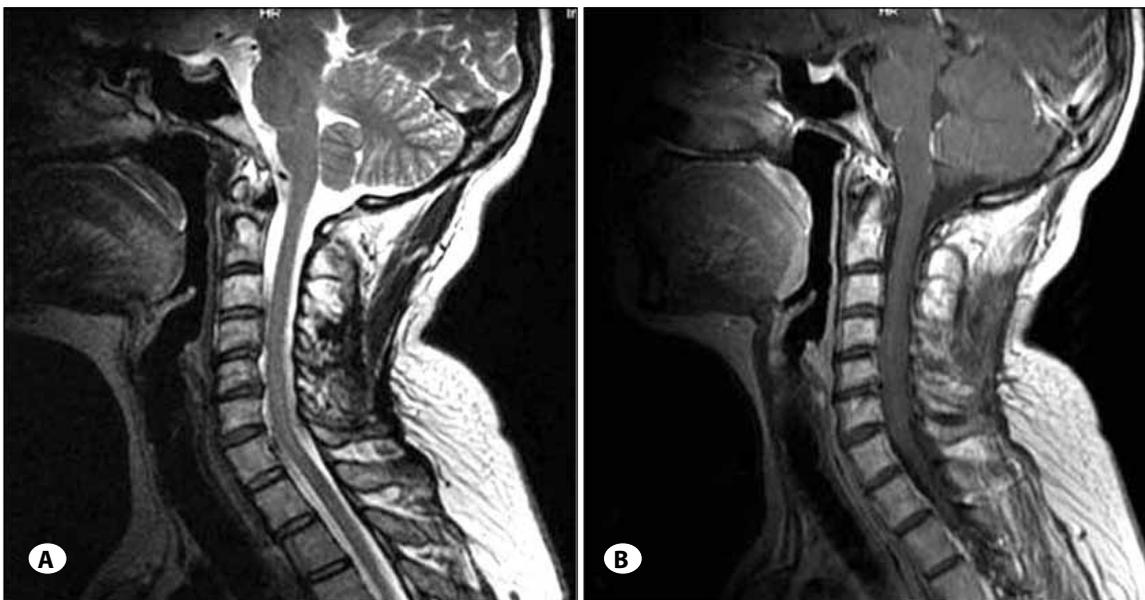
No tumor recurrence in T2-weighted sagittal scan (A) and enhanced T1-weighted sagittal scan (B).
